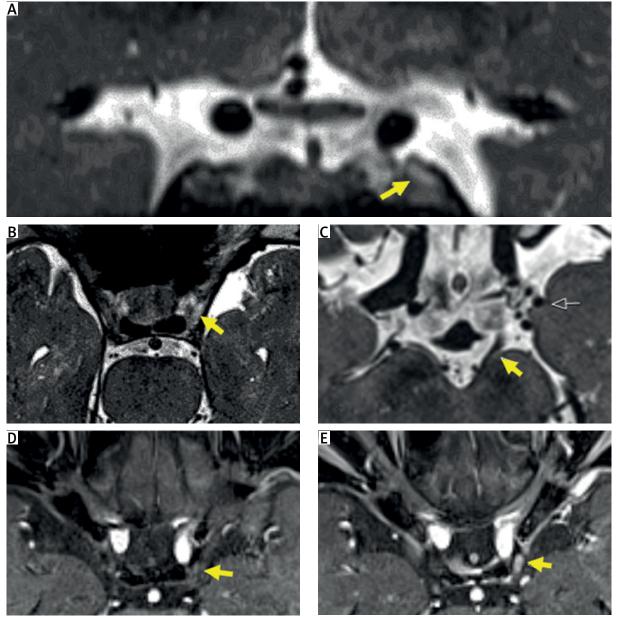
Brain MRI: coronal (A) and axial (B) T2-weighted images showing thickening and hyperintensity of the left oculomotor nerve. On another heavily T2 weighted axial plane (C), it's possible to identify the aneurism of the left posterior communicating artery (black arrow), without anatomical relation with the oculomotor nerve pathway (yellow arrow). Additionally, it also exhibited avid enhancement on postgadolinium fat-saturated T1 weighted images (D, E).
